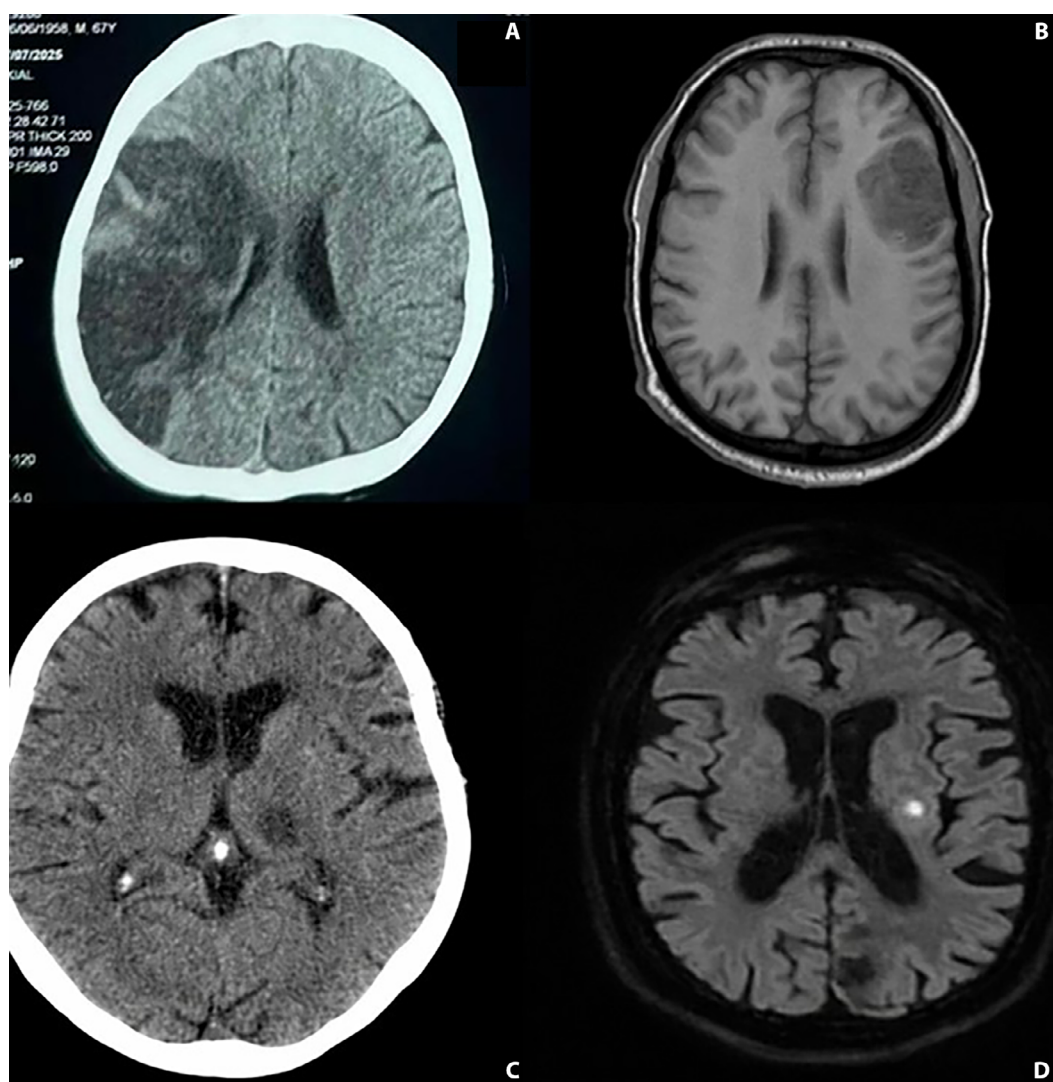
Brain CT and MRI findings demonstrating lacunar and non-lacunar infarct subtypes.
